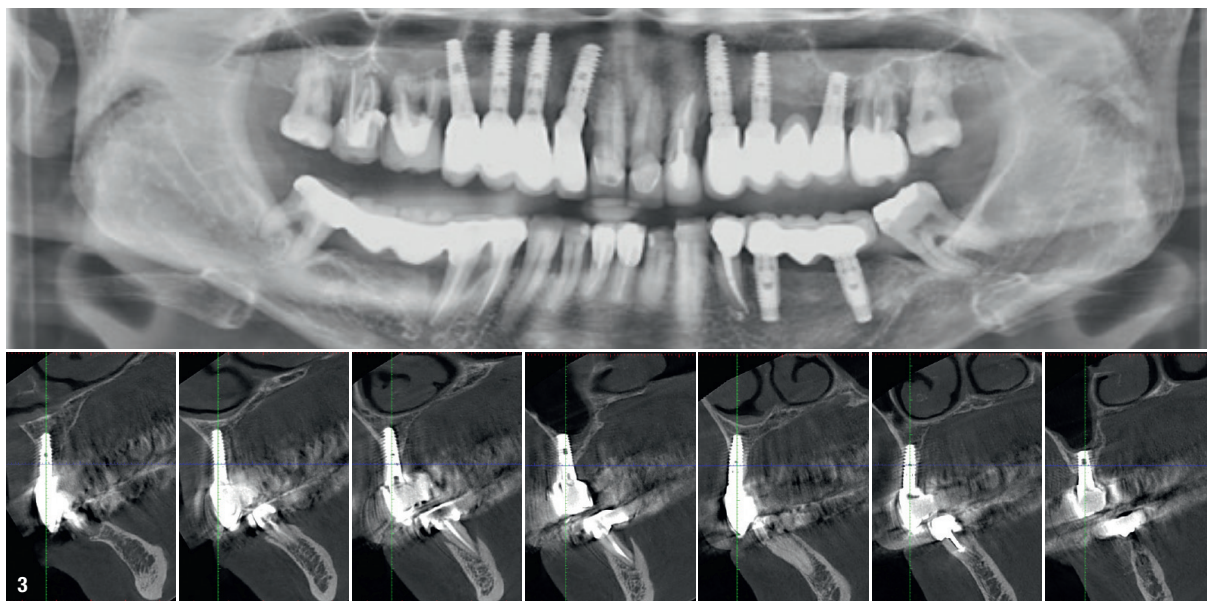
Panoramic radiograph along with CBCT slides.
